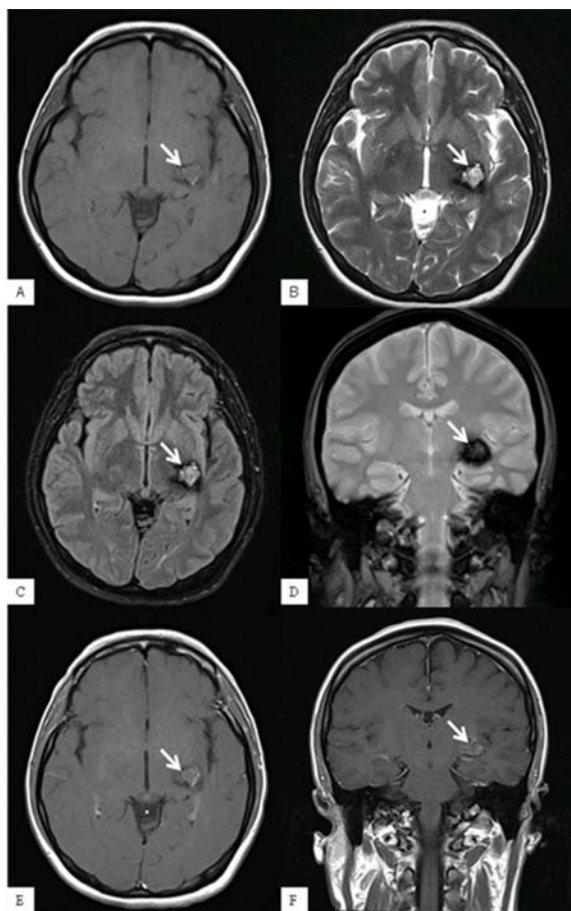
Contrasted MRI brain showed a 1.7x1.5x1.3 cm of “popcorn-like” or “raspberry-like” appearance, suggesting a cavernous angioma (arrow) in the posterior limb of the left internal capsule and the lateral part of the left thalamoganglionic region. (A) axial T1W, (B) axial T2W, and (C) FLAIR imaging. Coronal T2GRE (D) showed a peripheral hemosiderin ring and partial enhancement after gadolinium injection (E and F).
